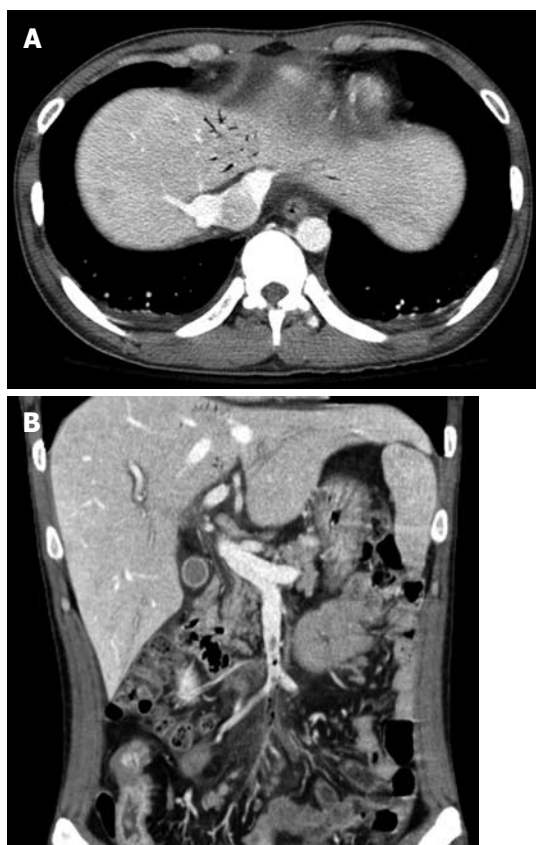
Computed tomography of the abdomen showing evidence of (A) portal venous gas, and (B) superior mesenteric venous gas and thrombus.
